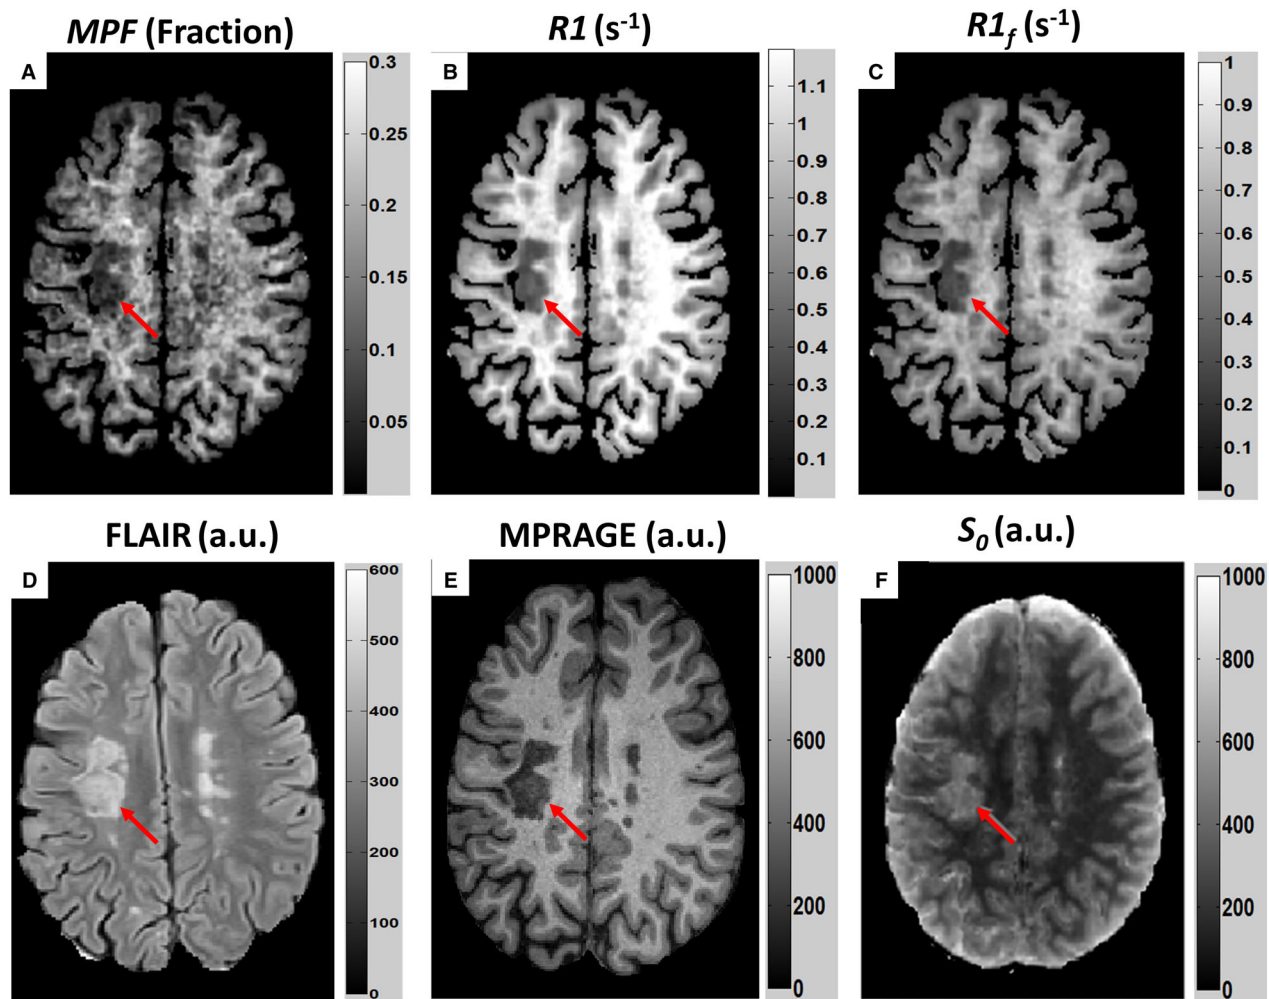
Examples of axial SMART metrics images alongside axial FLAIR and MPRAGE images. Macromolecule proton fraction (MPF) [units range from 0 (no bound protons) to 1 (no free protons)] (A), $R1$ ($1/s$) (B), $R1_f$ (the longitudinal relaxation rate of the free pool), (C), FLAIR (a.u.) (D), MPRAGE (a.u.) (E) and S_0 (a.u.) (F) images were obtained from a 34 year-old man with MS since age 16, now with non-relapsing secondary progressive MS (EDSS 7.5). One focal lesion is indicated by a red arrow. MPF images, as well as $R1$, $R1_f$ and MPRAGE images, showed hypointense (reduced) signals at sites of lesions. Proton density (S_0) and FLAIR showed hyperintense signals at sites of lesions. SMART images do not exactly match FLAIR due to different slice thicknesses (1 mm for SMART and 3 mm for FLAIR). a.u. = arbitrary units. Note that the major advantage of SMART is not in detecting lesions but in quantitative assessment of tissue damage in normal-appearing tissue as presented in Table 2 and Figure 2.
